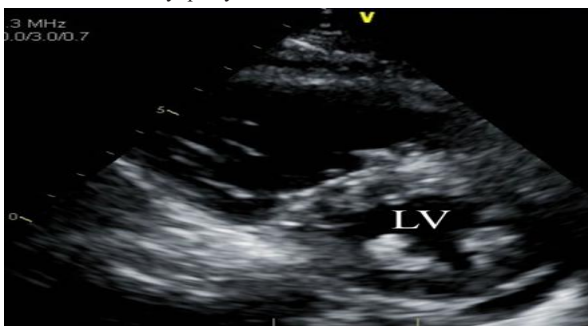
Parasternal short-axis view confirming apical hypokinesis.
